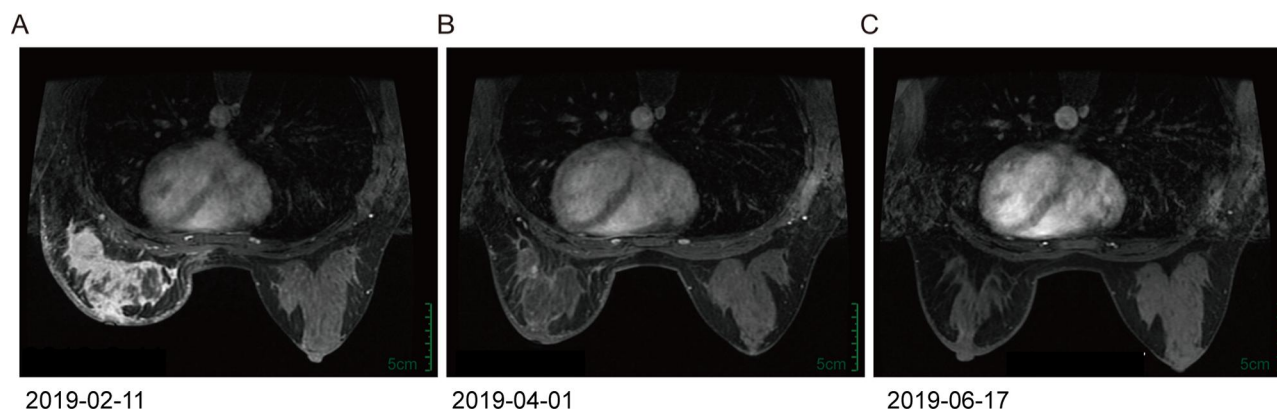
Breast MRI imaging. Notes: (A) MRI presents with a left breast mass (8.7cm in diameter) which was apparently intensified before treatment. (B) The imaging was scanned after 2-cycle treatment with PTPC (the combination of pyrotinib, trastuzumab, paclitaxel and cisplatin). It shows us a significant decrease in lesion size (0.7cm in diameter) and visibly reduced lymph node size in the left armpit, which was evaluated as a clinical partial response (cPR). (C) After 4-cycle treatment with PTPC, the imaging results were similar to those seen in the right breast on the imaging, suggesting a response close to a clinical complete response (cCR).
